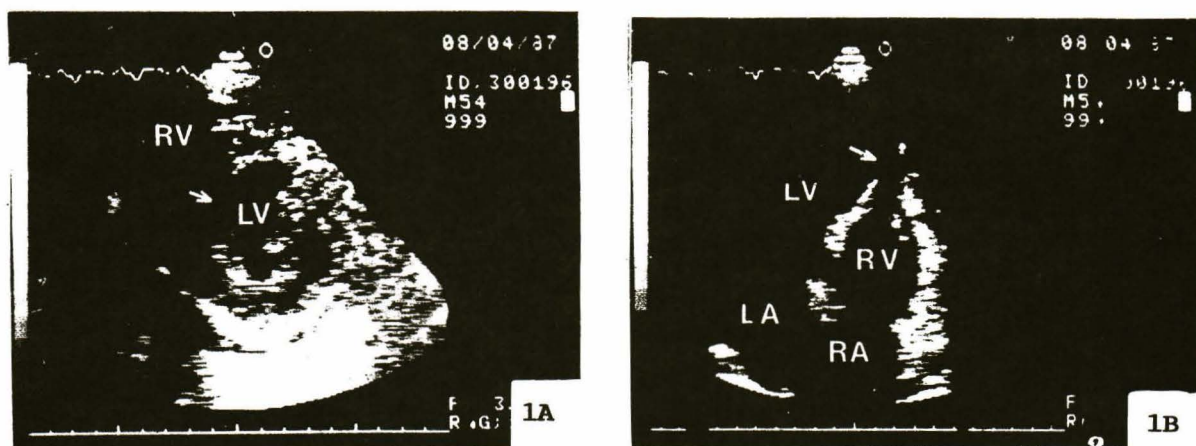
2D - echocardiogram from patient number 4 showed ruptured of apical septum (arrow), in short axis (A), and apical four chamber view (B).
